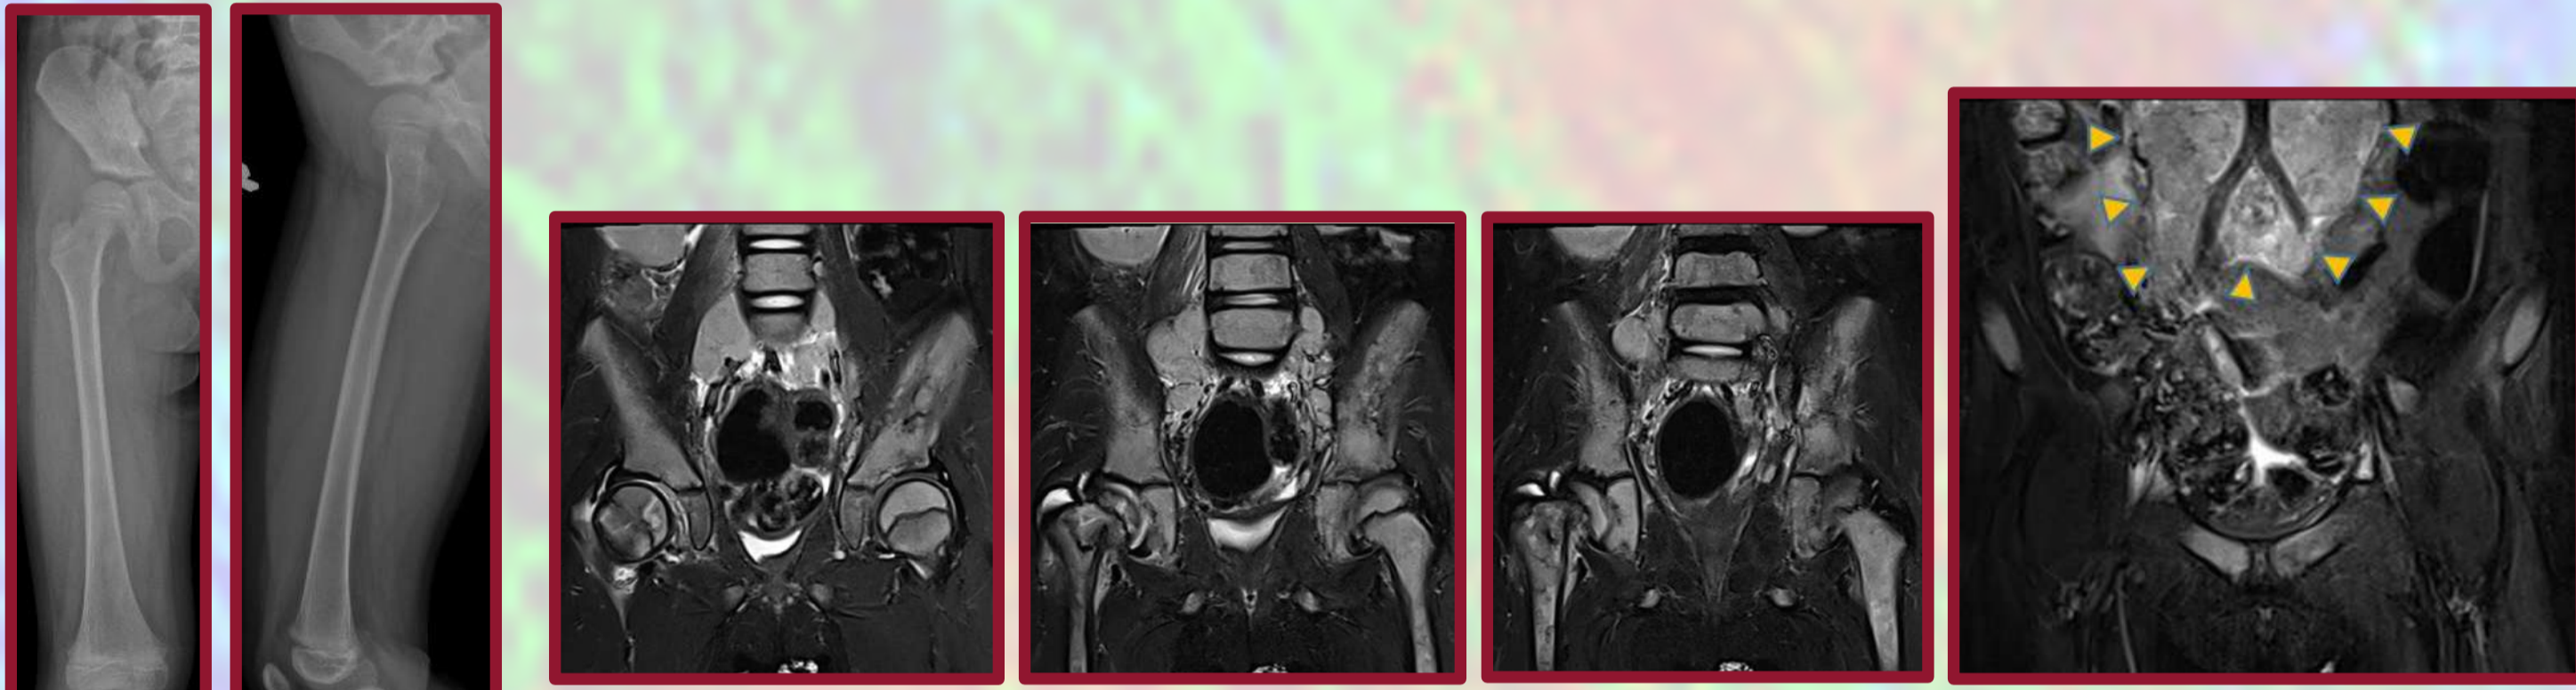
Initial radiographs of the right femur shows a normal right hip joint and no cortical lesion in the right femur.
